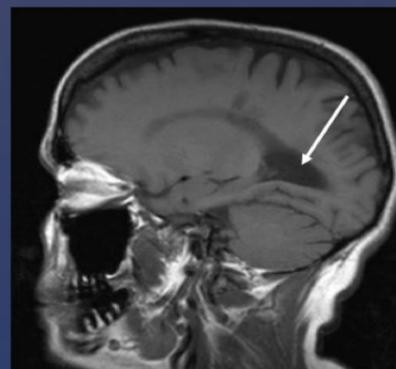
This T1 weighted MRI shows a darkened area of demyelination within the normally bright appearing myelin.⁴
